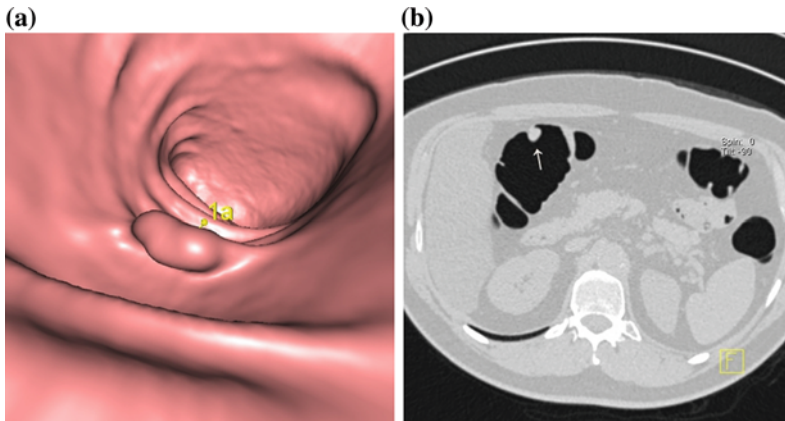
Colonic adenoma with pathological confirmation in a patient who underwent CT colonography as a screening test. a 3-D image shows a polypoid lesion (1a).
